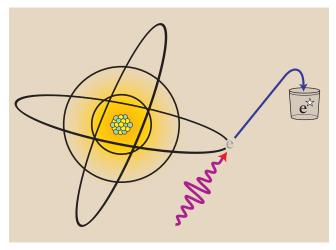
X-ray interaction with a photostimulable phosphor results in excitation of electrons into a metastable state.
